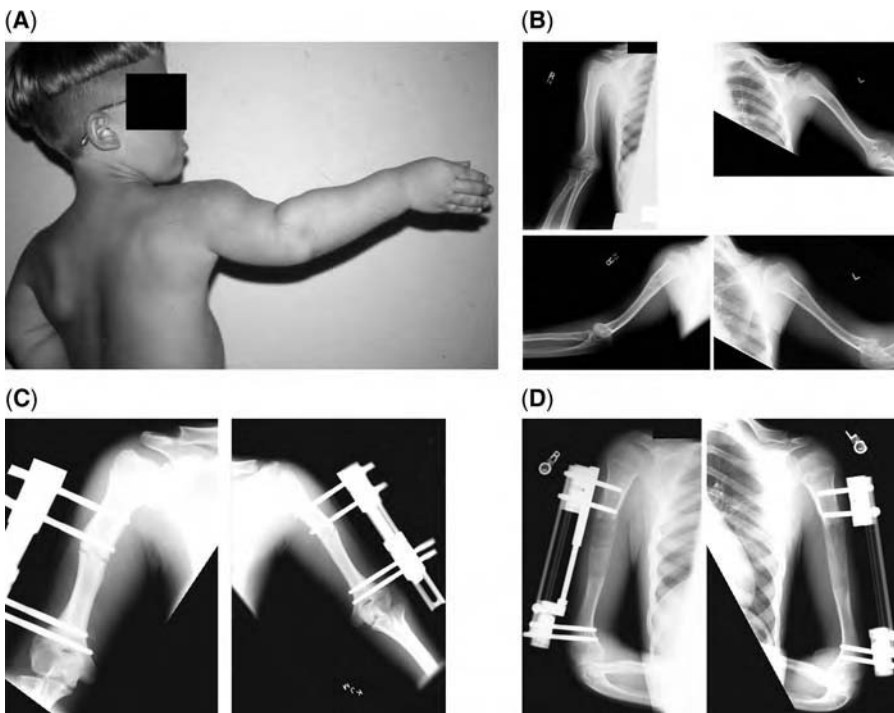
(A) Rhizomelic shortening is characteristic of achondroplasia. The humerus is disproportionately shorter than the forearm. The elbow lacks full extension. (B) Preoperative radiographs of a 16-year-old achondroplastic boy who underwent bilateral humeral lengthening. (C) Bilateral monolateral four-pin fixators applied. (D) Anteroposterior view of both humeri at the end of consolidation phase. About 8 cm of new bone has been achieved. (E) Fracture at the host-regenerate bone junction on the right side occurred from a fall one month postremoval of fixators. Intraoperative sequence of fracture reduction, reaming with flexible hand held reamer, and stabilization with Rush pin.
